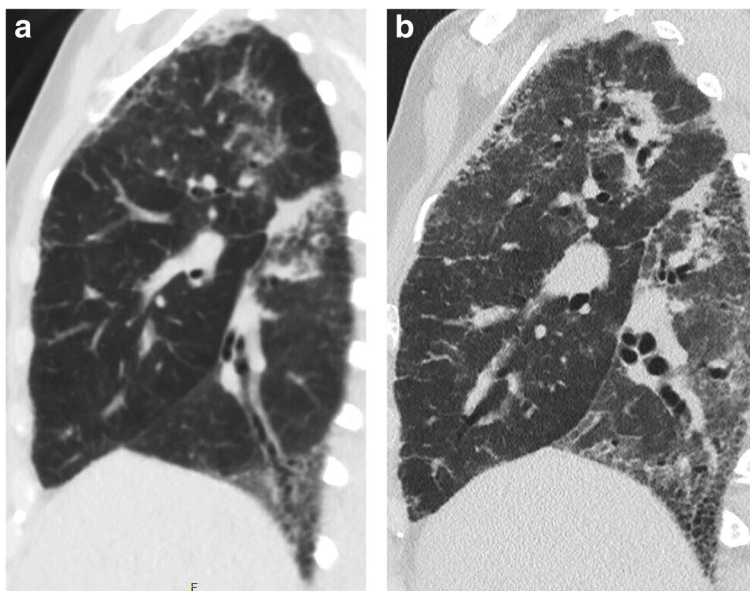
High-resolution computed tomography (sagittal plane) of the chest showing worsening of lung fibrosis with thickening of peribronchovascular interstitium, bronchiectasis, reticulations, honeycombing, ground glass opacities and lung parenchyma consolidations. Initial examination (a) and three-month follow-up (b)
